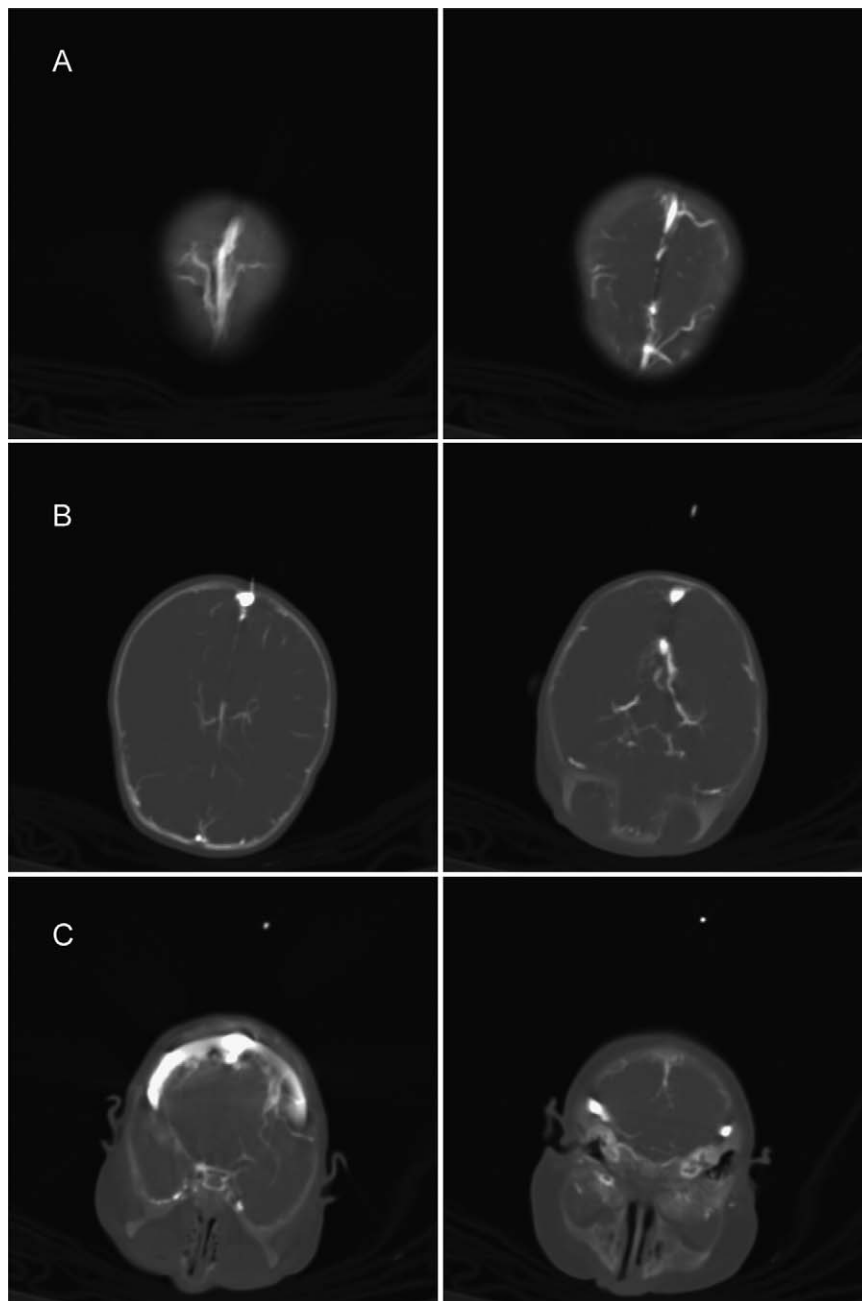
CT images of the contrast fluid filled sinus sagittalis superior with upper and lower bridging veins (A), deep cerebral veins (B) and sinus transversus and jugular veins (C).
